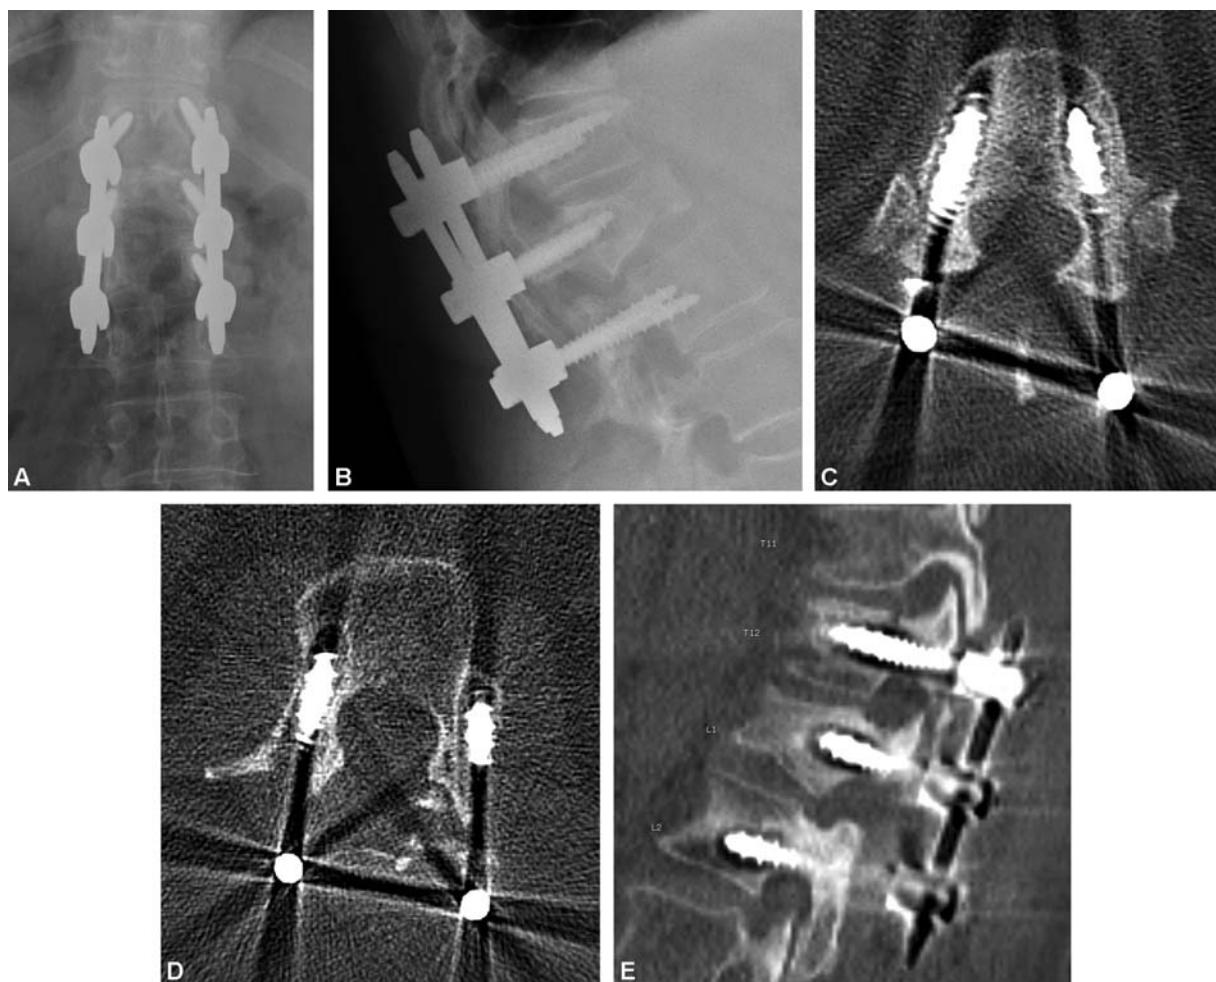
A 57-year-old woman with diffuse large B-cell lymphoma and pathologic fracture of L1, 2 years postoperatively from posterior laminectomy and instrumented fusion T12–L2 and postoperative radiation therapy to the surgical site. Static AP and lateral radiographs (A,B) demonstrate loosening of pedicle screw instrumentation, as indicated by haloing around the screws. Haloing is confirmed by axial fine-cut CT scan at T12 and L2 (C,D) with sagittal reconstruction (E).
